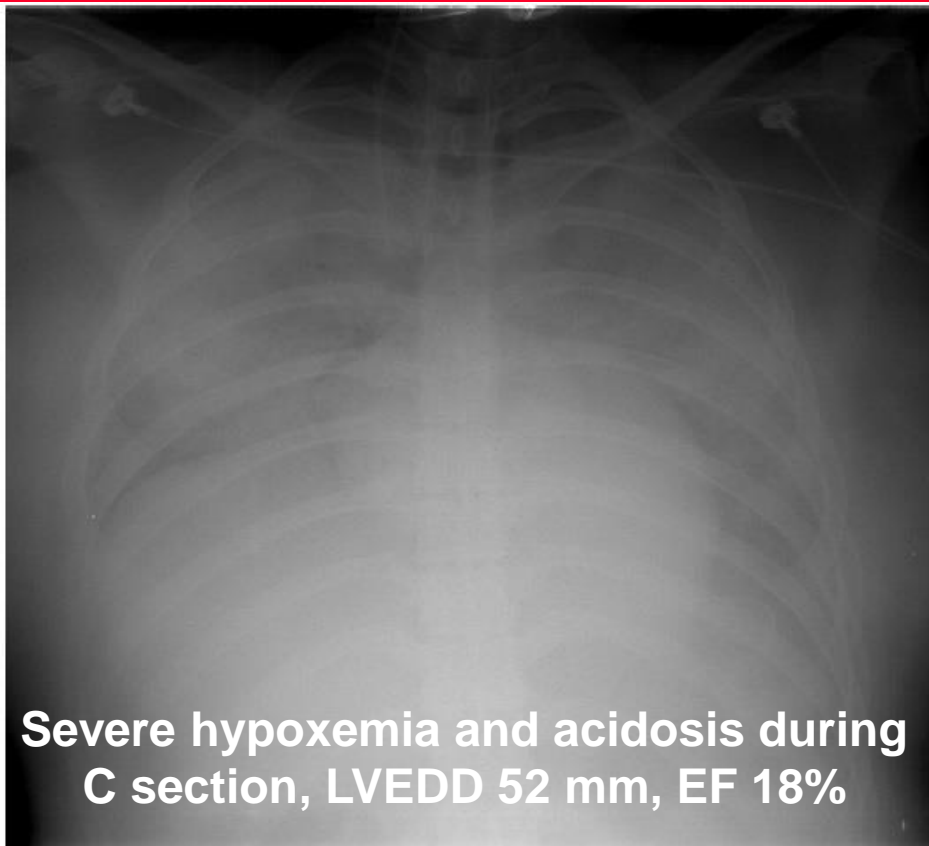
Severe pulmonary edema was shown in the chest x-ray taken at admission.
